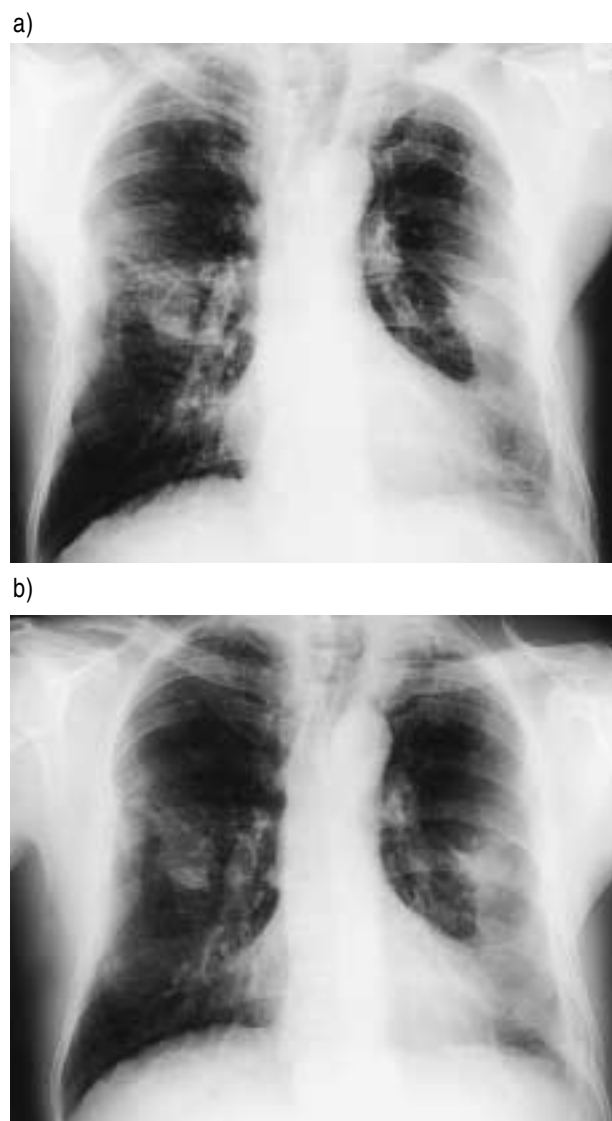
Chest radiographs of patient No. 15, frontal view. a) At presentation: extensive plaques are seen on the right side, and diffuse pleural thickening on the left side, together with bilateral rounded atelectasis. b) Two months after withdrawal of bromocriptine: there is a small improvement, but extensive pleural fibrosis remains.
